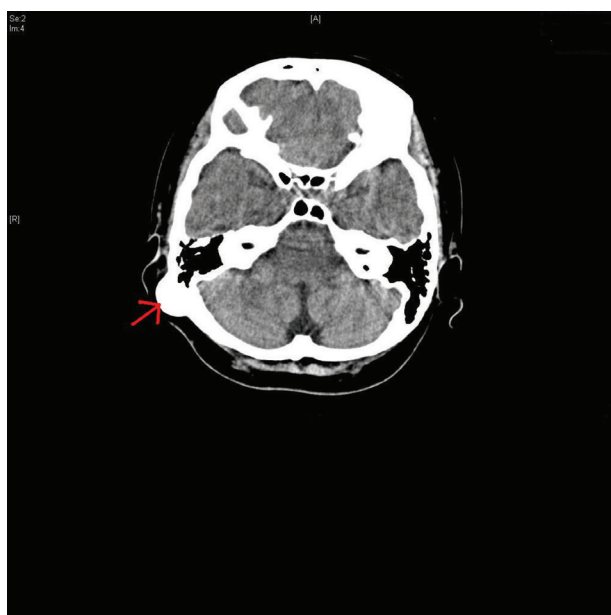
Axial section of CT scan showing osteoma at the right mastoid region.
